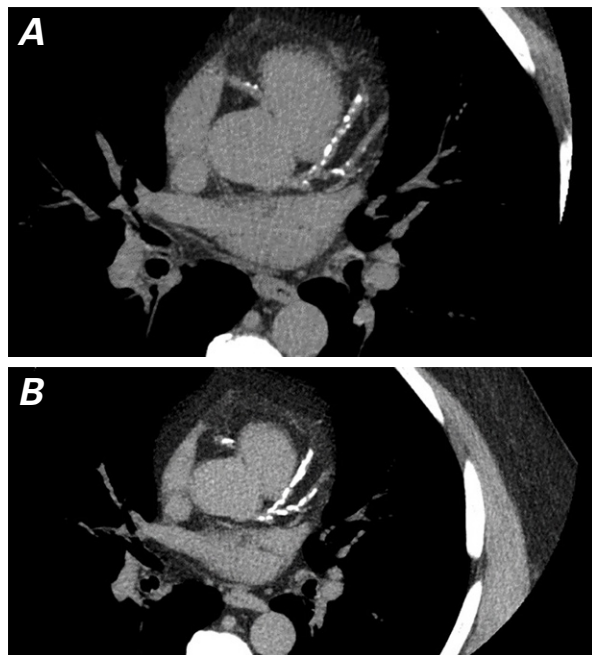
Computed tomographic coronary artery calcium scan (axial view) acquired during A) 64-slice scanning shows less coverage and inferior image quality when compared with B) 256-slice scanning.
